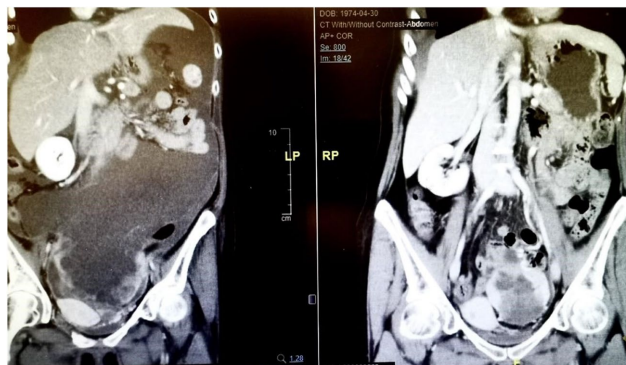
Coronal contrast-enhanced CT scan obtained post-myomectomy demonstrating some heterogenous signal intensity within the uterine myometrium, raising suspicion for residual STUMP.
